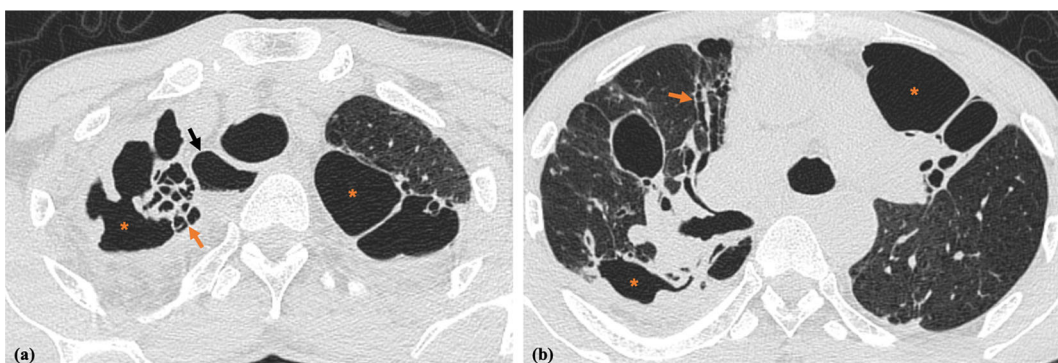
Chronic cavitating aspergillosis in a 58-year-old patient with a clinical history of tuberculosis several years ago and alcoholism, now presenting with low-grade fever and cough for more than three months. CT scan in lung window from an upper (a) and lower level (b) reveals multiple bilateral cavities (orange
